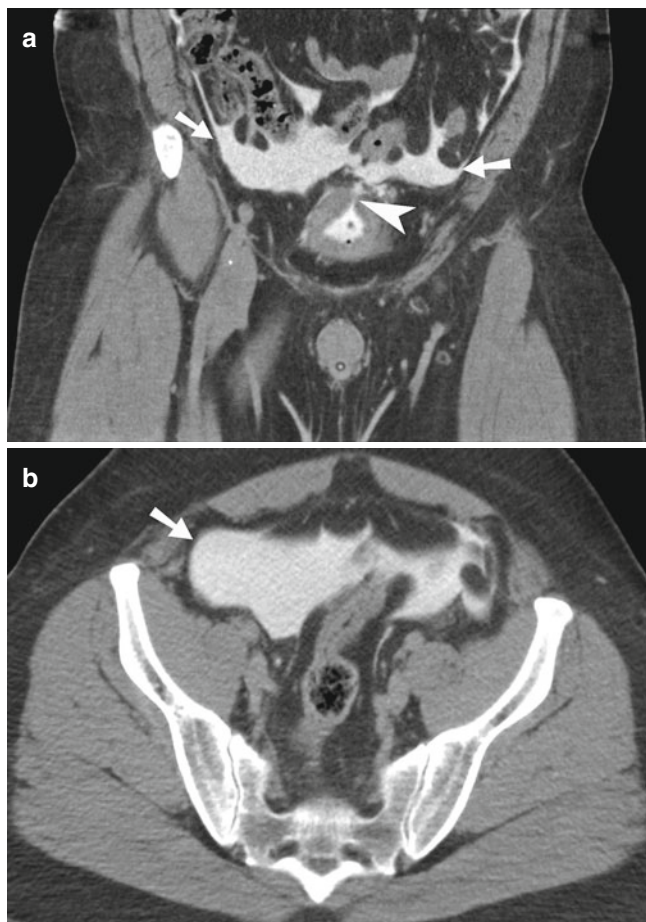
Intraperitoneal bladder rupture. (a and b) Coronal CT cystogram image demonstrating large amount of intraperitoneal contrast (arrows) leaking from the dome of the urinary bladder (arrowhead) and outlining the small bowel loops
